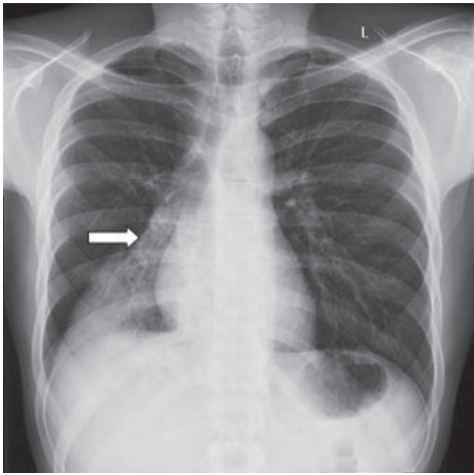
Chest radiograph frontal projection shows consolidation with significant collapse of the right lower lobe(right arrow).
